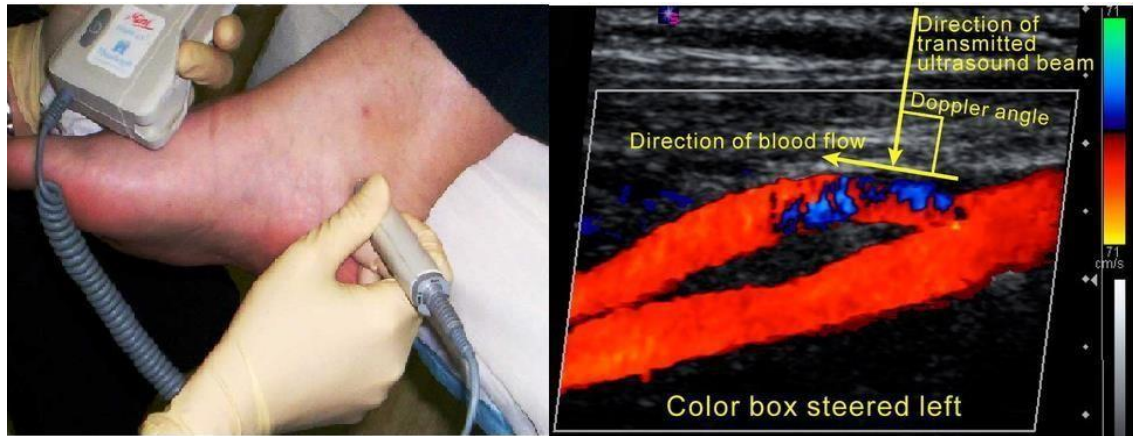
(Left) Operation of Doppler Ultrasound, (Right)Result of Doppler Ultrasound
